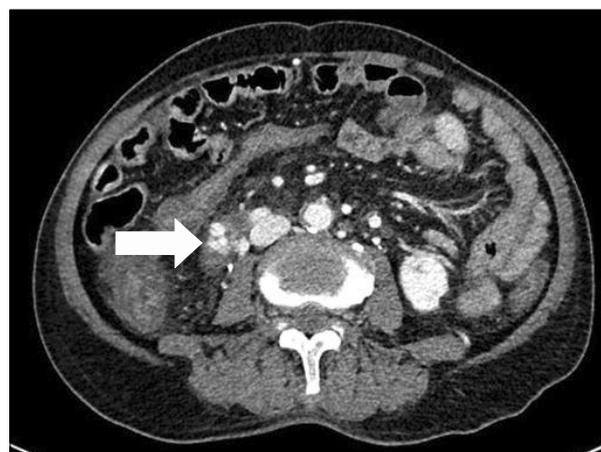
In the third portion of the duodenum, multiple dilated varices (arrow) were detected on contrast enhanced CT angiography.
